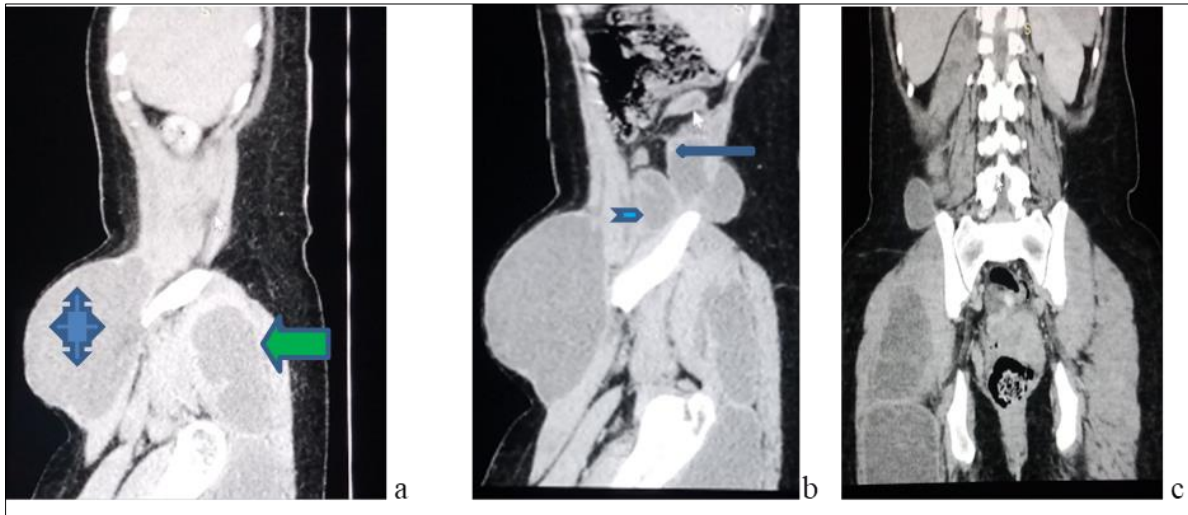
b are reformatted sagittal non-contrast enhanced and contrast enhanced CT scan images and c is reformatted coronal contrast enhanced CT scan views showing both the flank/subcutaneous bulge/collection(four edged blue arrow), the gluteal region collection(big green arrow) and the psoas(slimmed body red arrow)/iliopsoas muscle(chevron blue arrow) collection/abscesses
